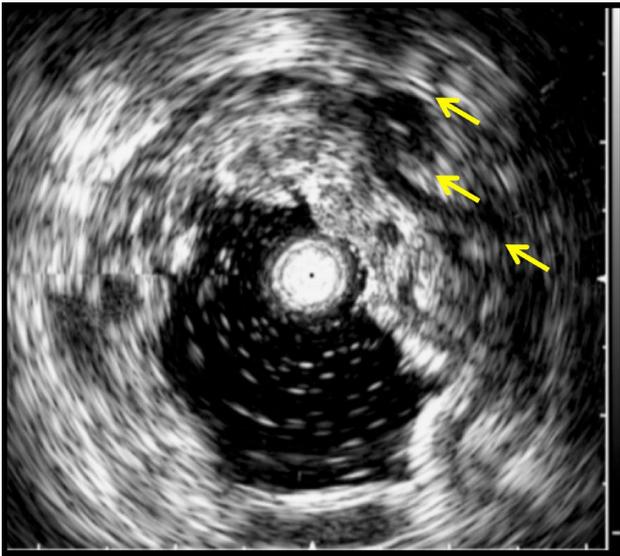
Ultrasonogram showing dilated vessels in the submucosal layer (arrows)
